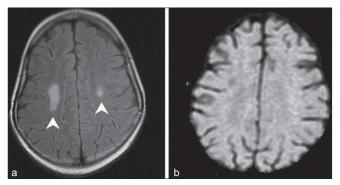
FLAIR- (a) and diffusion-weighted image (b) from the follow-up study shows appearance of hyperintensities in the region of the centrum semiovale (arrowheads in a) and resolution of restricted diffusion seen in the earlier study in Figure 1
